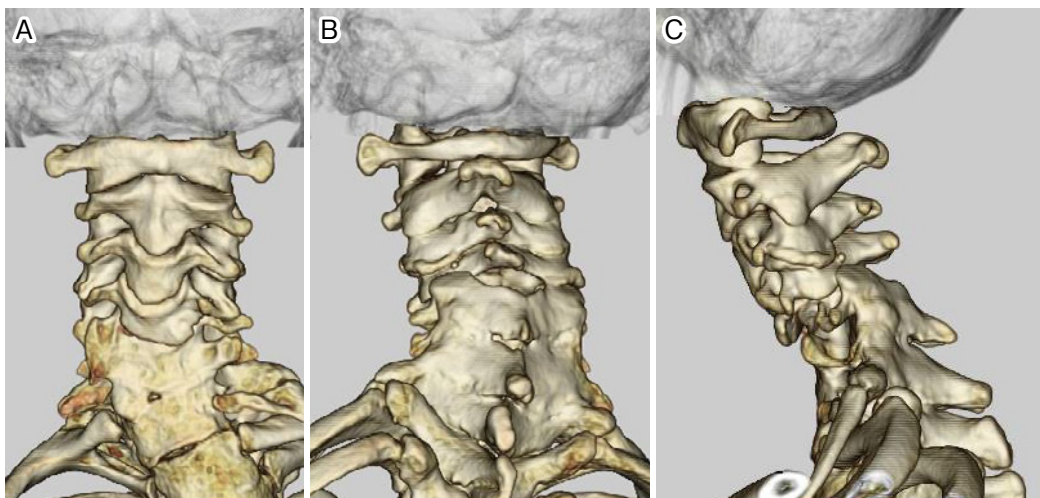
Three-dimensional Computed Tomography (3DCT)
